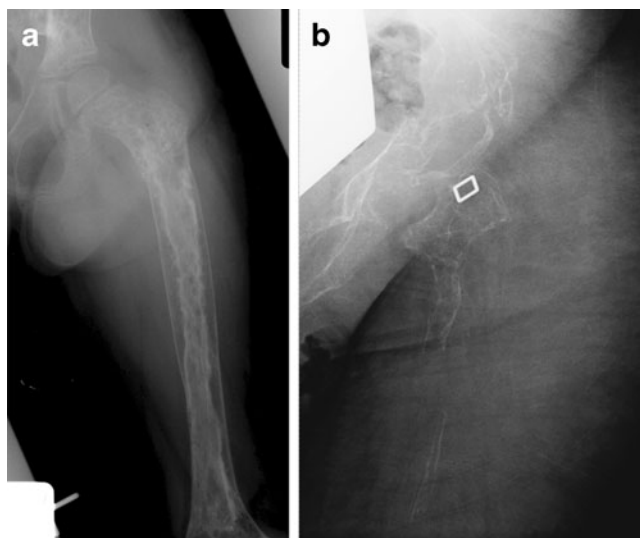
Frontal radiographs of the femur in a female patient with Gorham-Stout disease. a At age 5 years: Lytic lesions are seen in the left pelvis and femur, with evidence of endosteal scalloping and cortical thinning b At age 18 years: There is massive progressive osteolysis with almost complete resorption of the left femur, ischium, and ilium
